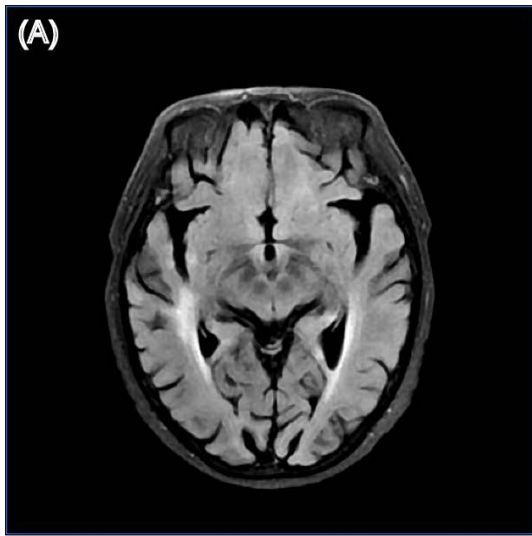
Structural brain MRI images of patient 03. (A) T2-weighted fluid-attenuated inversion recovery (T2-FLAIR) image; (B) Gadolinium-enhanced T1-weighted (Gd-T1w) image.
